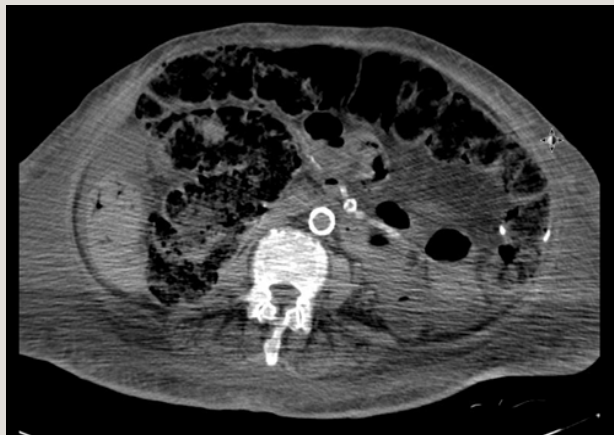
CT abdomen showing extensive vessel calcification, bowel dilatation, wall edema, and pneumatosis intestinalis
